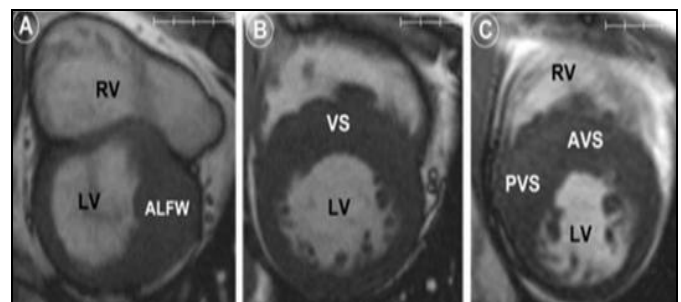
CARDIAC MRI IMAGES SHOWING PATTERNS OF LV HYPERTROPHY
